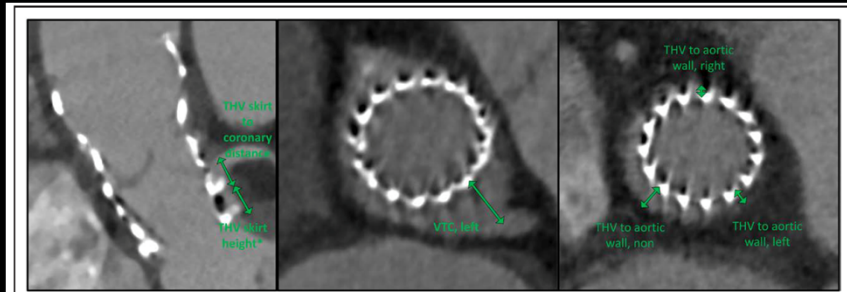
Computed tomographic images with measurements used to calculate the risk of obstruction and feasibility of coronary access.
